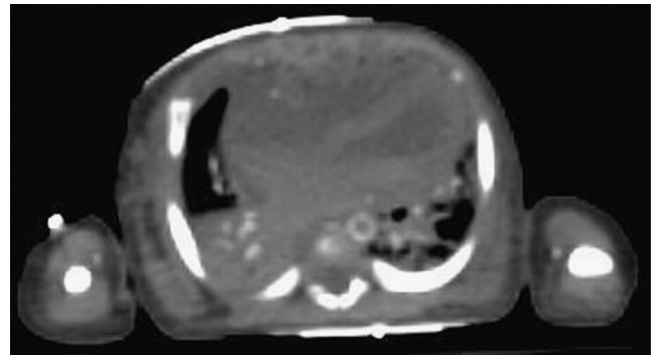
Axial CT demonstrates cardiomegaly and bibasal atelectasis. There is also calcification of coronary arteries, aorta, pulmonary artery and upper limb arteries bilaterally.
